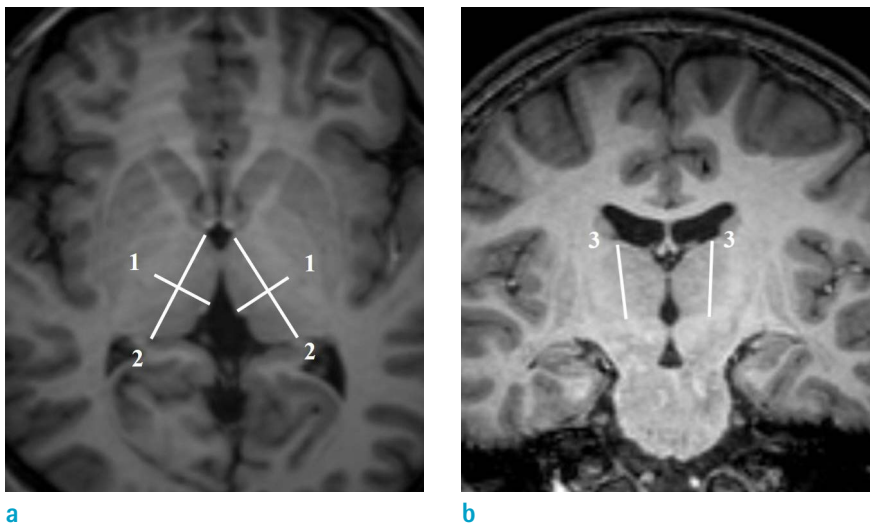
(a) An axial T1-weighted image of a 13-year-old child with Krabbe disease. Line 1 refers to transverse length and line 2 refers to anterior-posterior length. (b) A coronal T1-weighted image in the same patient. Line 3 indicates cranio-caudal dimension.
